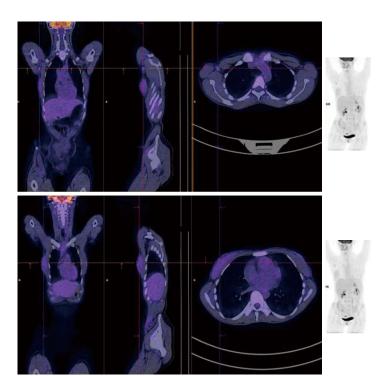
Positron emission tomography/low-dose X-ray computed tomography (positron emission tomography/low-dose computed tomography) with F-18 FDG. Focal accumulation is observed in enlarged lymph nodes of the right axillary region and diffuse uptake is observed in the right breast.
